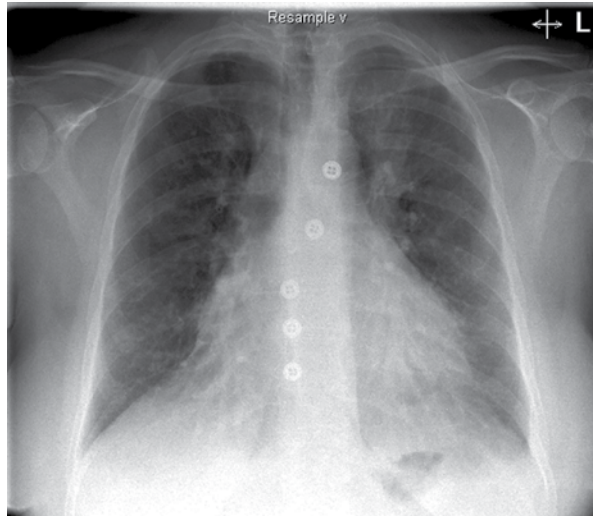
Chest x-ray showing left upper zone airspace opacification and an area of increased density overlying the head of the left posterior fifth rib.
